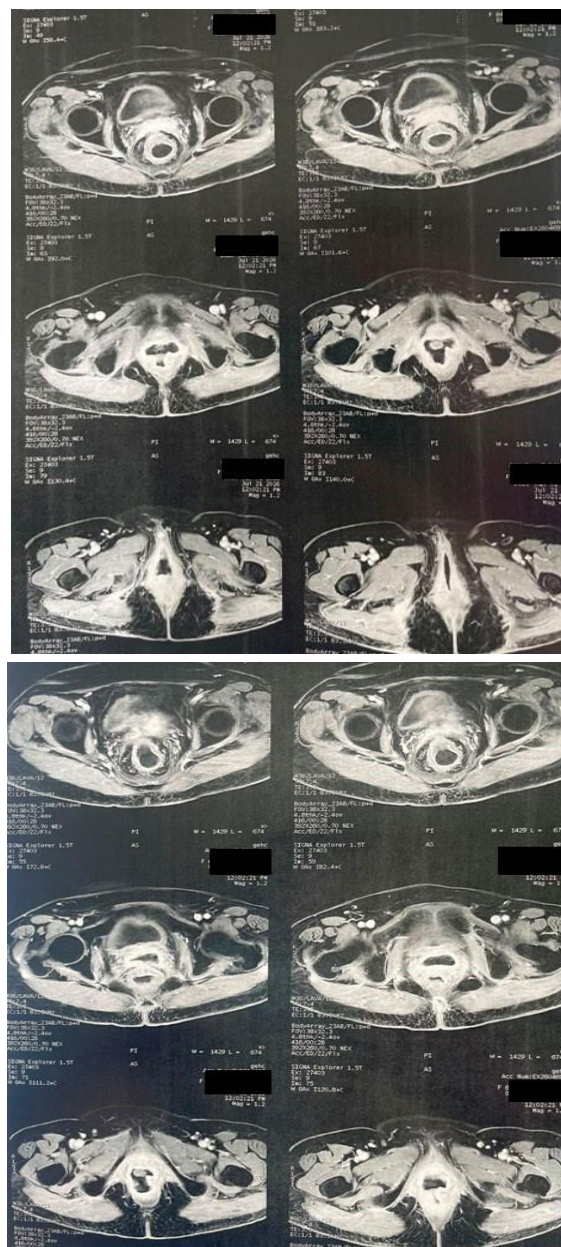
Pelvic MRI of our patient showing the rectovaginal fistula.
